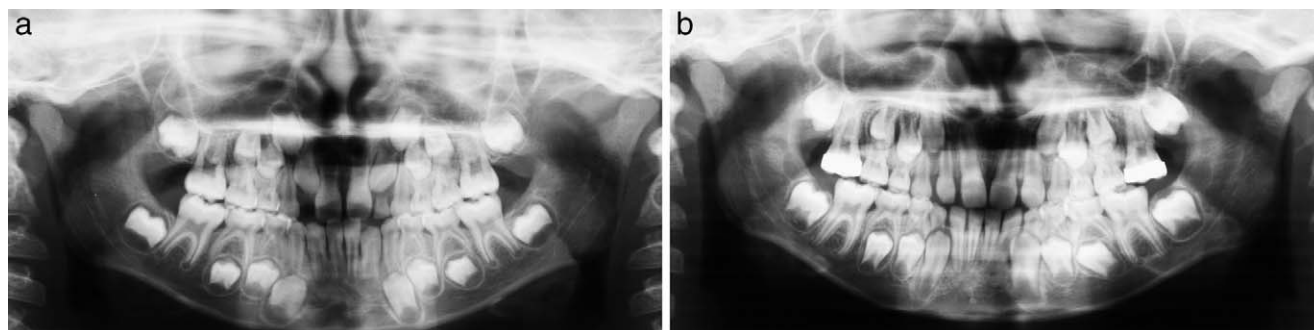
Orthopantomograms of a patient treated with a cervical HG, taken at the baseline (a) and after 2-year follow-up (b).
